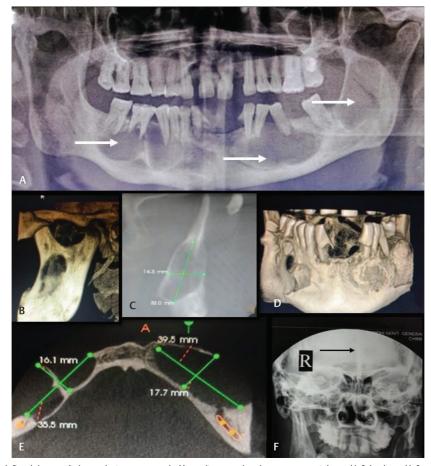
(A) OPG shows well-defined three radiolucent lesions surrounded by radiopaque border present on right and left body and left ramus of the mandible. There is pathological migration of lower premolars on either side of mandible. No evidence of any root resorption. (B) Three-dimensional (3D) image reconstruction of left ramus. (C) Coronal section of left ramus showing expansion of lingual cortical plate with lesion measuring approximately (32.2 mm × 14 mm) in its maximum dimension. (D) 3D image reconstruction of mandible. (E) Axial section measuring approximately (35.5 mm × 16.1 mm and 39.5 mm × 17.7 mm) at its greatest dimension on right and left side respectively. (F) AP view skull showing ectopic calcification of falx cerebri. AP, anteroposterior; OPG, orthopantomogram.
